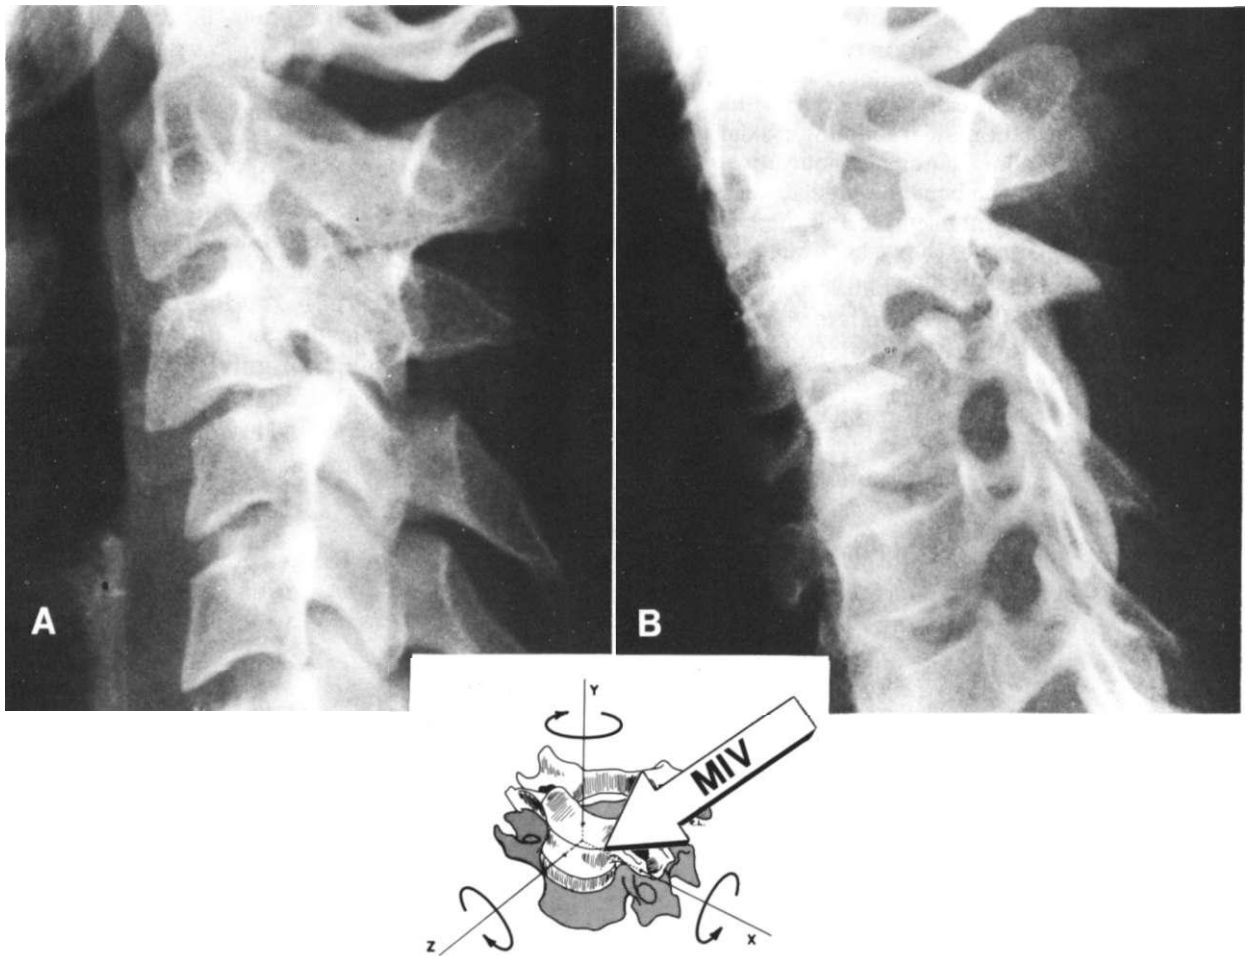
Radiographs of young male who sustained a unilateral fracture dislocation of the left facet. (A) The anterior subluxation, which includes a significant element of rotation. (B) This oblique view shows the fracture of the caudal portion of the left articular facet, which actually involved a small portion of the lamina. This was observed at the time of surgical exploration. The MIV for this injury has caused flexion, compression, and axial rotation. (There is respective $+x$ -axis rotation, $-y$ -axis compression force, and $-y$ -axis torque.) The mechanism here is similar to that shown in Figure 4-36, but here there is a greater compressive force. The compressive force accounts for fracture of the facet (fracture dislocation) rather than pure unilateral facet dislocation.
